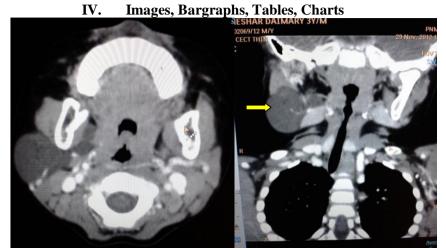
Cystic hygroma. Contrast enhanced CT of neck in a 3 year old body showing cystic lesion in the right side of neck.
